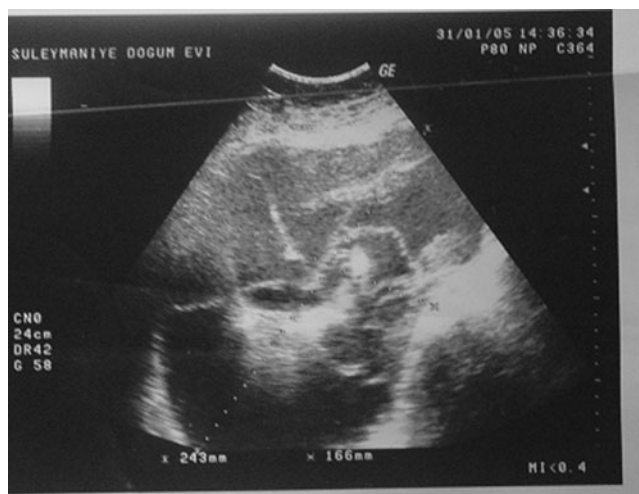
Ultrasonographic appearance of endometrioma
